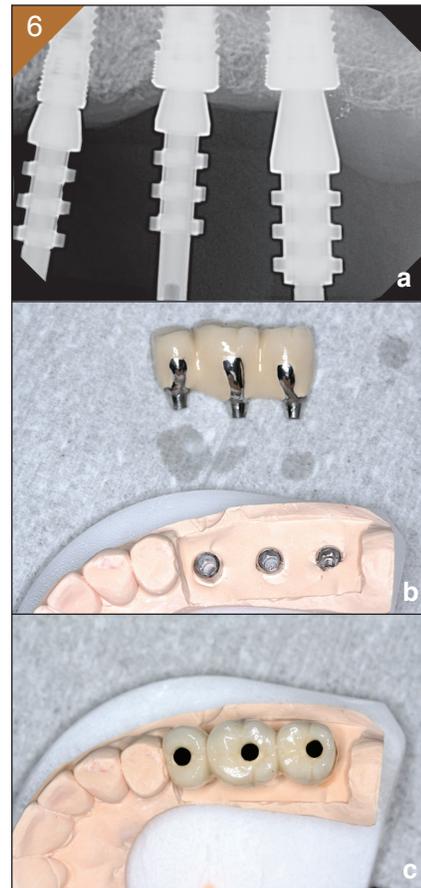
a) Radiographic verification of the seated open tray impression copings over the implants, b) The final prostheses fabricated with three non-engaging UCLA abutments, c) Occlusal view of the three connected screw-retained implant crowns on the verified maxillary cast.
